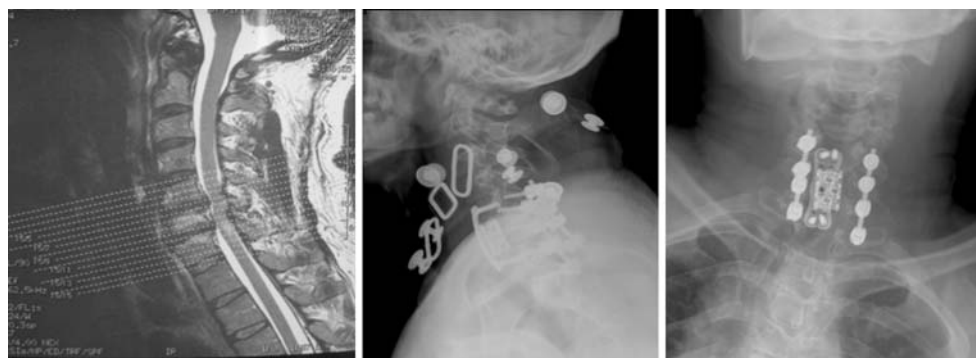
Patient #3. Pre-operative sagittal T2-weighted MRI and postoperative radiographs: circumferential decompression and fusion for cervical stenosis without instability
